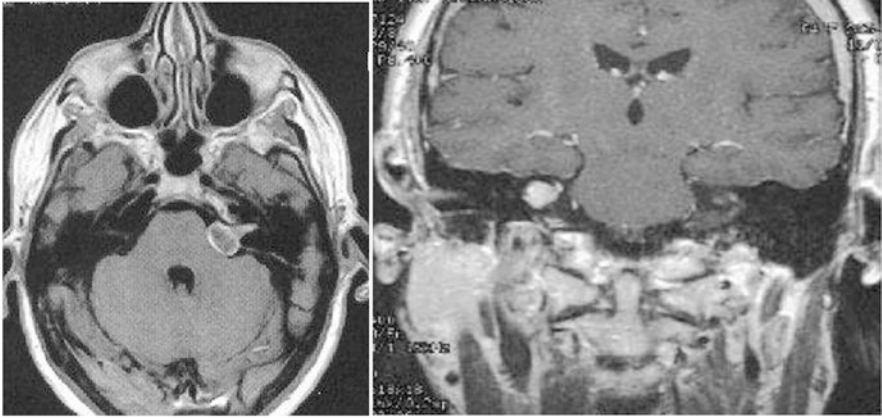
MRI brain with cerebello-pontine angle showing CP angle lesion-acoustic schwannoma
